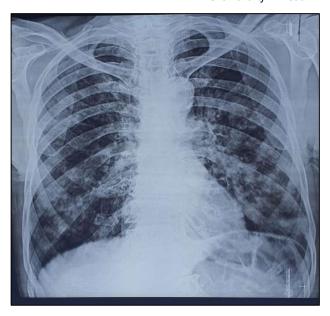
Chest X-ray-diffuse bilateral alveolar infiltrates
